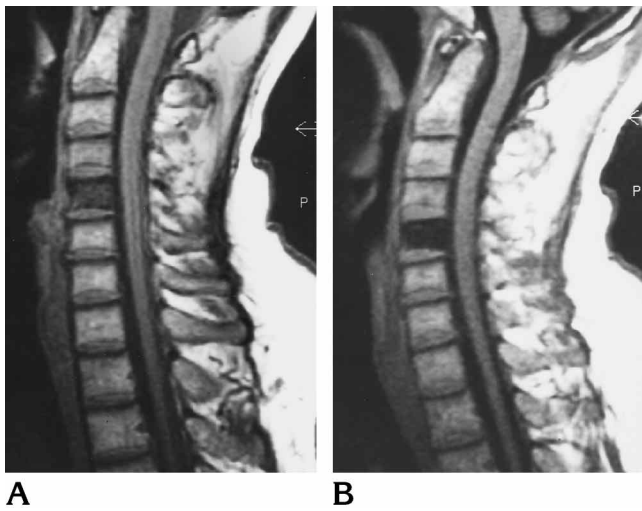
A 53-year-old woman with metastatic breast cancer. Both the sagittal T1-weighted SE (500/20/4) (A) and the sagittal T1-weighted fast FLAIR (2000/10 effective/4, TI of 862, echo train length of 6) (B) sequences showed a low-SI lesion completely replacing the marrow of the C-5 vertebral body, consistent with metastases. Note the greater contrast between the lesion and marrow and less internal detail of the vertebral body on the FLAIR sequence.
